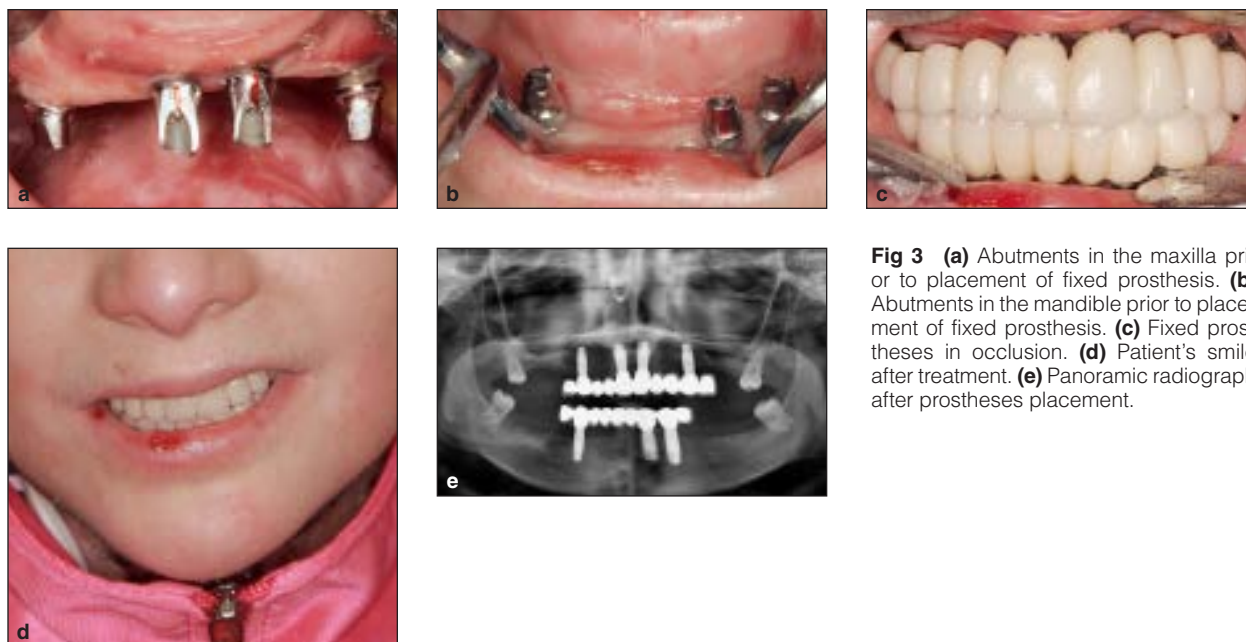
(a) Abutments in the maxilla prior to placement of fixed prosthesis. (b) Abutments in the mandible prior to placement of fixed prosthesis. (c) Fixed prostheses in occlusion. (d) Patient's smile after treatment. (e) Panoramic radiograph after prostheses placement.
